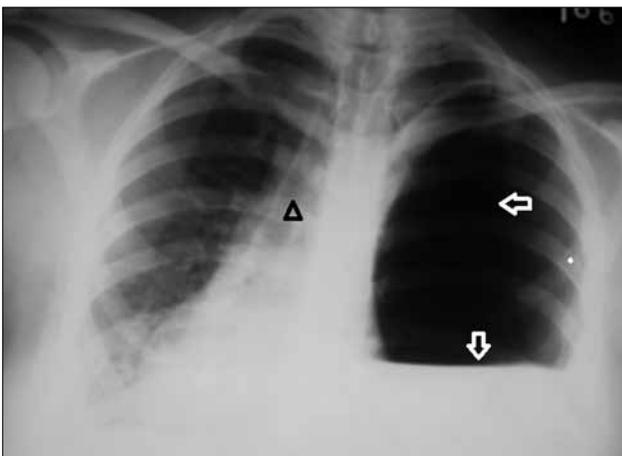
Left tension gastrothorax. Chest X-ray of a 28-year-old pregnant female shows herniation of the stomach into the left hemithorax (horizontal arrow), with air fluid level (vertical inverted arrow) and mediastinal shift to the right side (arrow head).
